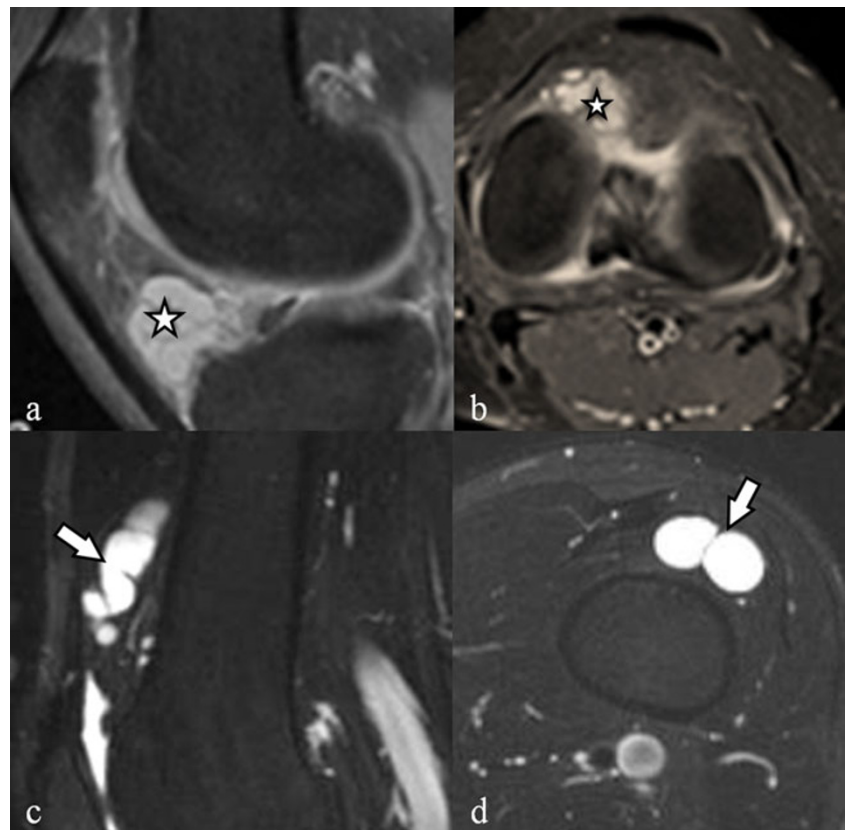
Hoffa's fat pad ganglion cysts*: the sagittal (a) and axial (b) fat saturated proton density weighted images in two different patients demonstrate a multiloculated septated cystic lesion (asterisks) within the Hoffa's fat pad. *Ganglion cyst of the suprapatellar bursa*: the sagittal (a) and axial (b) fat saturated T2-weighted images show a lobulated cystic lesion (arrows) in the suprapatellar bursa
